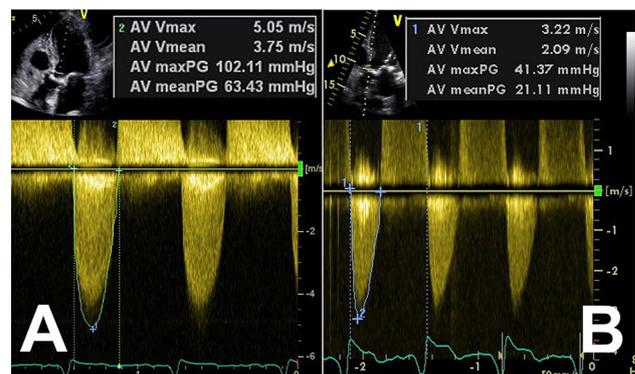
a Echocardiography of a patient with normal-flow, high-gradient aortic stenosis and b echocardiography of a patient with paradoxical low-flow, low-gradient aortic stenosis with preserved ejection fraction
